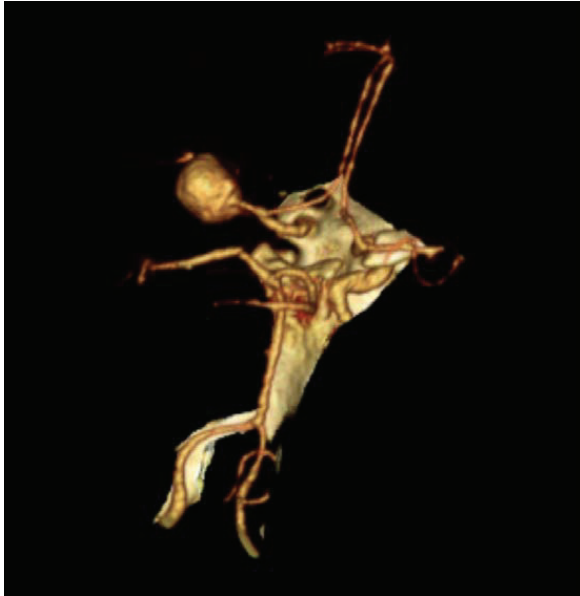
Reconstruction of CT angiography showing a large aneurysm in the left middle cerebral artery.
